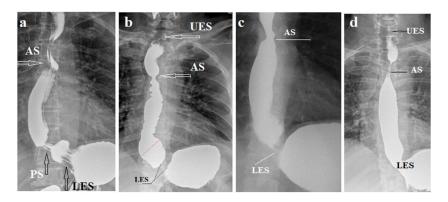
Radiographs of patients with GERD with non-esophageal symptoms, performed with the highest pressure in the stomach. All people have two anatomical sphincters in the esophagus: the upper esophageal sphincter (UES) and the lower esophageal sphincter (LES). In patients with GERD, physiological sphincters appear. The proximal sphincter (PS) arises over a dilated portion of the esophagus called the phrenic ampulla. It contracts to create high pressure in the ampulla for open the LES. It continues to contract until the ampulla injects its contents into the stomach. The pressure in the ampulla must be higher than the gastric pressure. If during the ampulla contraction, PS relaxes, the contents of the stomach are thrown into the esophagus. This is how transient LES relaxations occur during swallowing saliva. The PS also contracts during acid reflux to prevent the bolus from leaking into the proximal esophagus. The second barrier to the penetration of the acid bolus into the pharynx is the aortic functional sphincter (AS), which forms near the aortic narrowing of the esophagus. It occurs when PS is deficient. Dysfunction of the AS causes the reflux of acidic contents into the pharynx and the occurrence of non-esophageal symptoms. Details can be found here [6,7].
